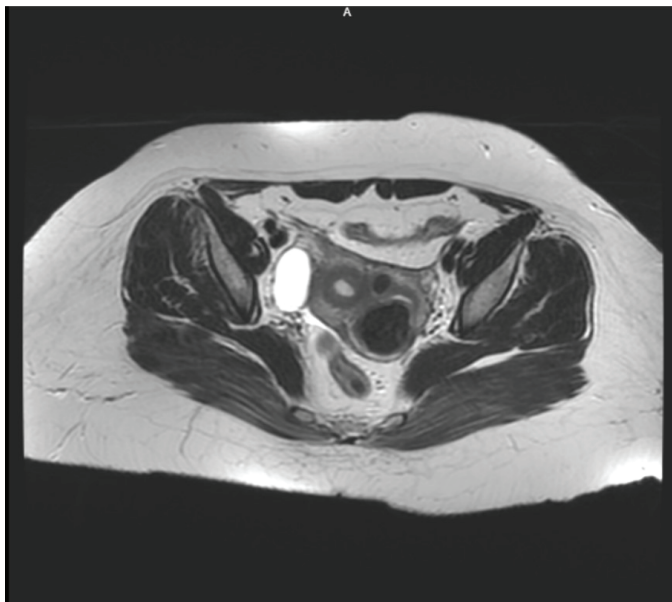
Shrunk leiomyoma with a diameter of 39 mm in the magnetic resonance imaging after 6 months of uterine artery embolization
